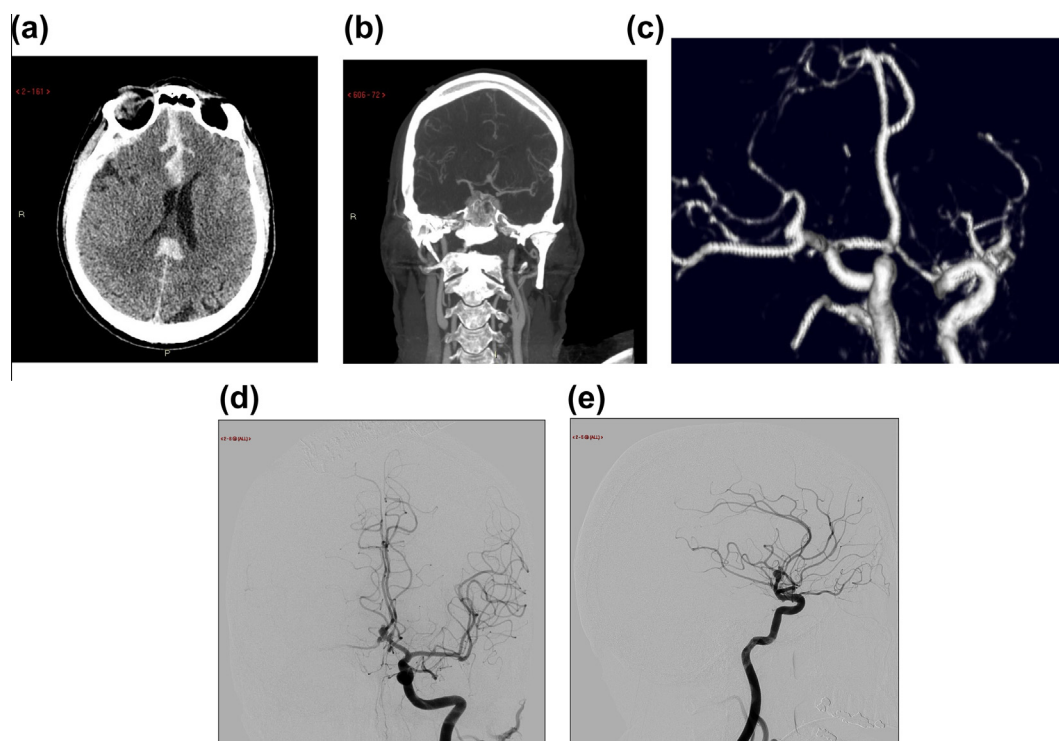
57-year-old female patient presented with severe headache and blurring of vision. (a) An axial non-contrast CT shows subarachnoid hemorrhage filling the interhemispheric fissures. (b) Coronal maximum intensity projection (MIP) image shows the aneurysm. (c) Oblique projection of a volume rendered reconstruction of the CEMRA shows a left anterior communicating artery aneurysm. (d and e) DSA of the left internal carotid artery.
